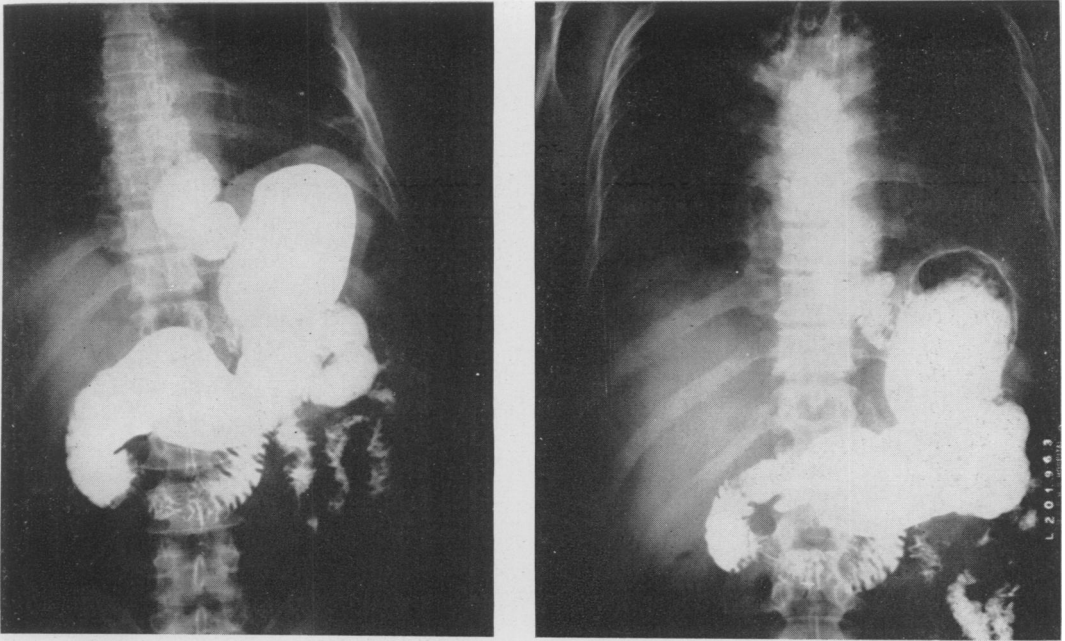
(M. C., Case 7.) In these postoperative roentgenograms the interposed segment gives a "coiled spring" appearance. The mobility and peristaltic activity of the segment is well demonstrated. Both factors are important in its behavior as a substitute sphincter.
